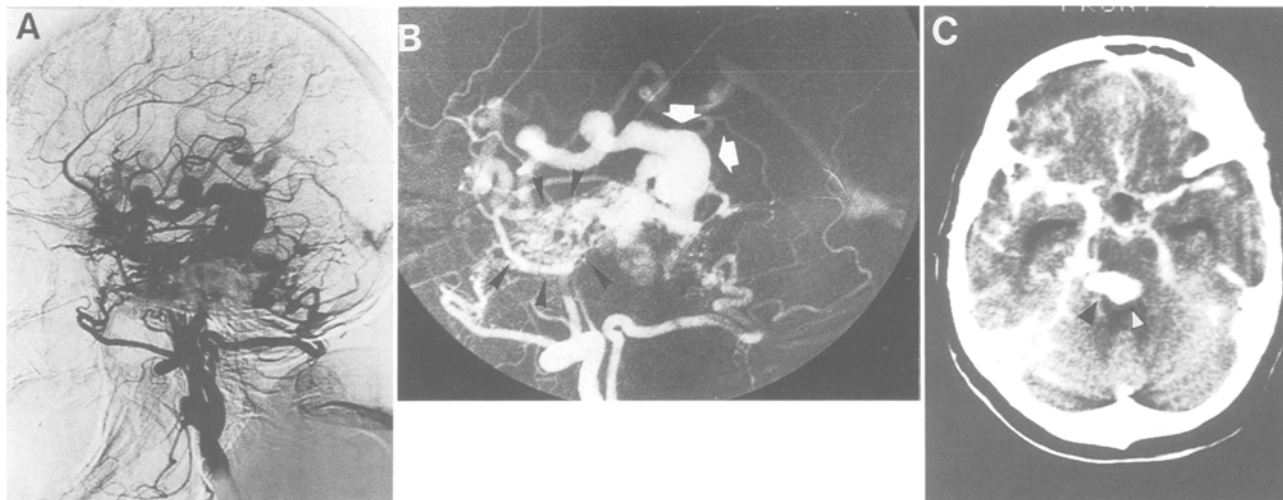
Unusual aggressive d'AVF (Case 9) located at the tentorial ring (A) on common carotid artery angiography; lateral view. Selective ECA-injection (B) shows the nidus clearly (arrows). Note the venous aneurysm (big arrows). Contrast-enhanced CT-scan (C) demonstrates the venous varix at the left tentorial incisura (arrows). This patient refused treatment initially and presented weeks later with intracerebral haemorrhage
